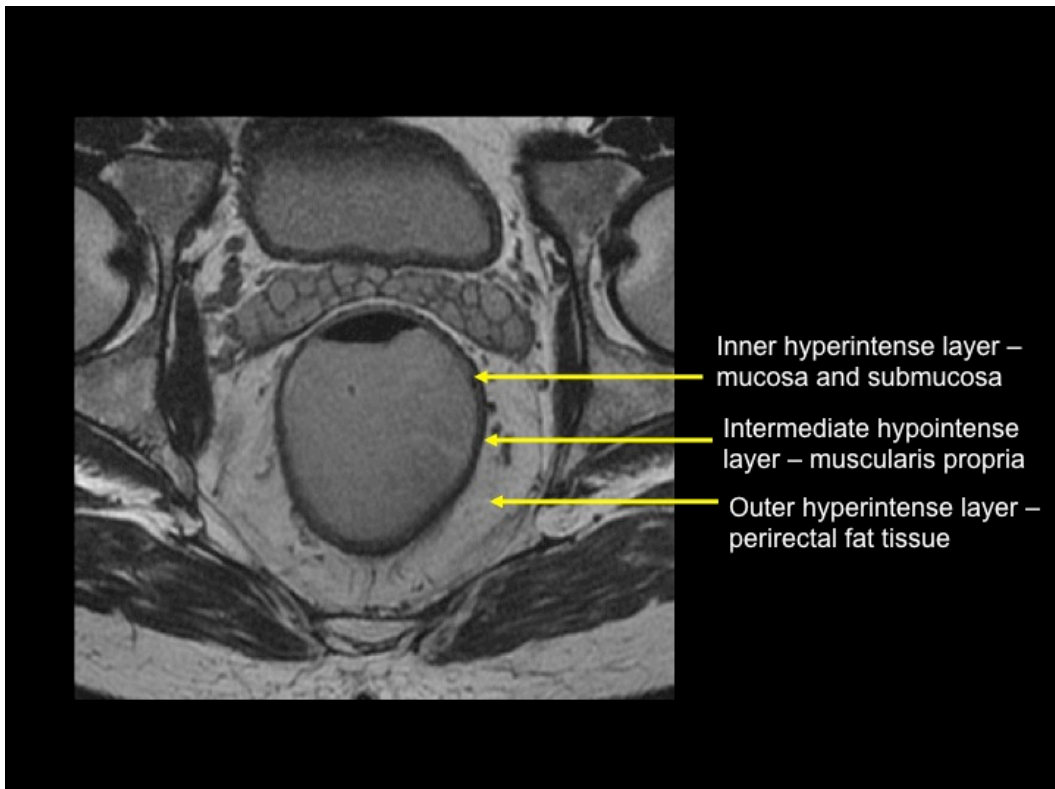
MR image of the rectal wall layers.
